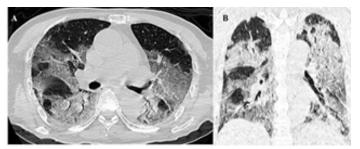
Images of an 85-year-old man with no history of COVID-19 vaccination, but with a history of hypertension. He complained of recurrent fever for five days, with the highest temperature reaching 39.5°C. (A-B) The chest CT scan reveals bilateral ground-glass opacity with consolidation, the extent of pneumonia was assessed as 21, with involvement in all five lobes. This case was classified as a typical manifestation of COVID-19, according to the RSNA chest CT classification system.
